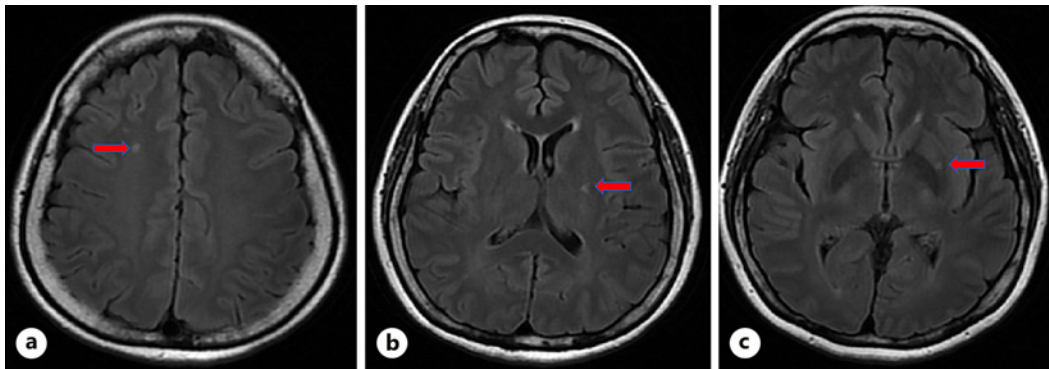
Brain MRI of the patient revealed the presence of multiple patchy and punctate hyperintense signals (bold red arrow) in the bilateral frontal lobes (a), left insular lobe (b), and left basal ganglia (c).
